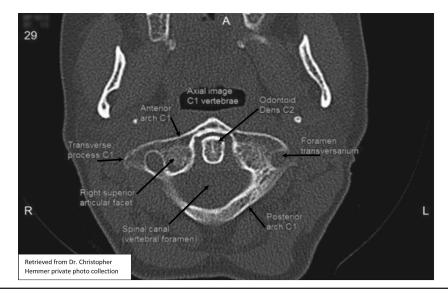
Axial CT of C1-2.
